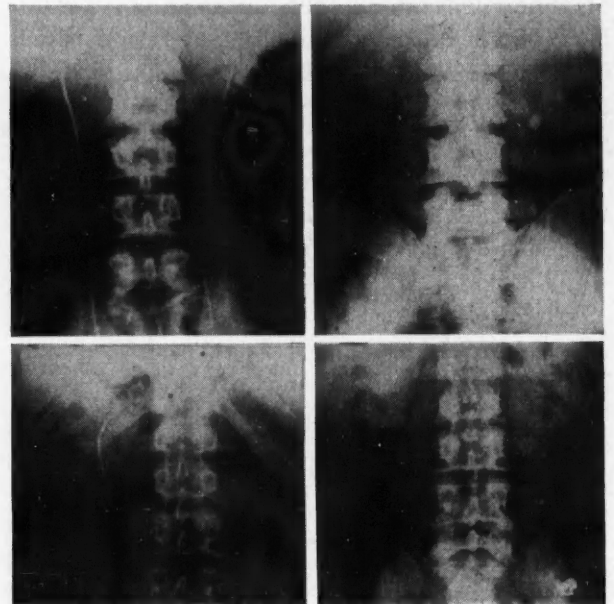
(Case 1).—X-ray 5 months after initial injury showing multiple calculi in left kidney. Fig. 2. (Case 1).—After irrigation with "G" solution the stones have broken into smaller particles and have migrated from the kidney to the ureter, giving rise to obstruction. Fig. 3. (Case 2).—X-ray more than 7 months after initial injury showing opaque shadow filling the minor calyces of the right kidney. Fig. 4. (Case 2).—X-ray following pelvic lavage with "G" solution shows complete disappearance of shadow in right kidney.
